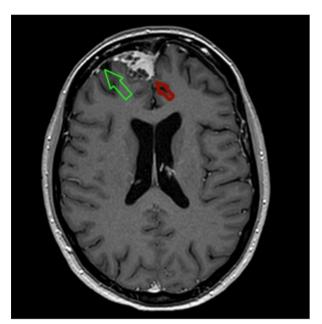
A contrast-enhanced cerebral magnetic resonance imaging section showing the right parafalcine nodular lesion already seen in the direct computed tomography scan (red arrow). Other dural areas of diffuse thickening and enhancement (known as "dural tail sign") are also visible (green arrow).
